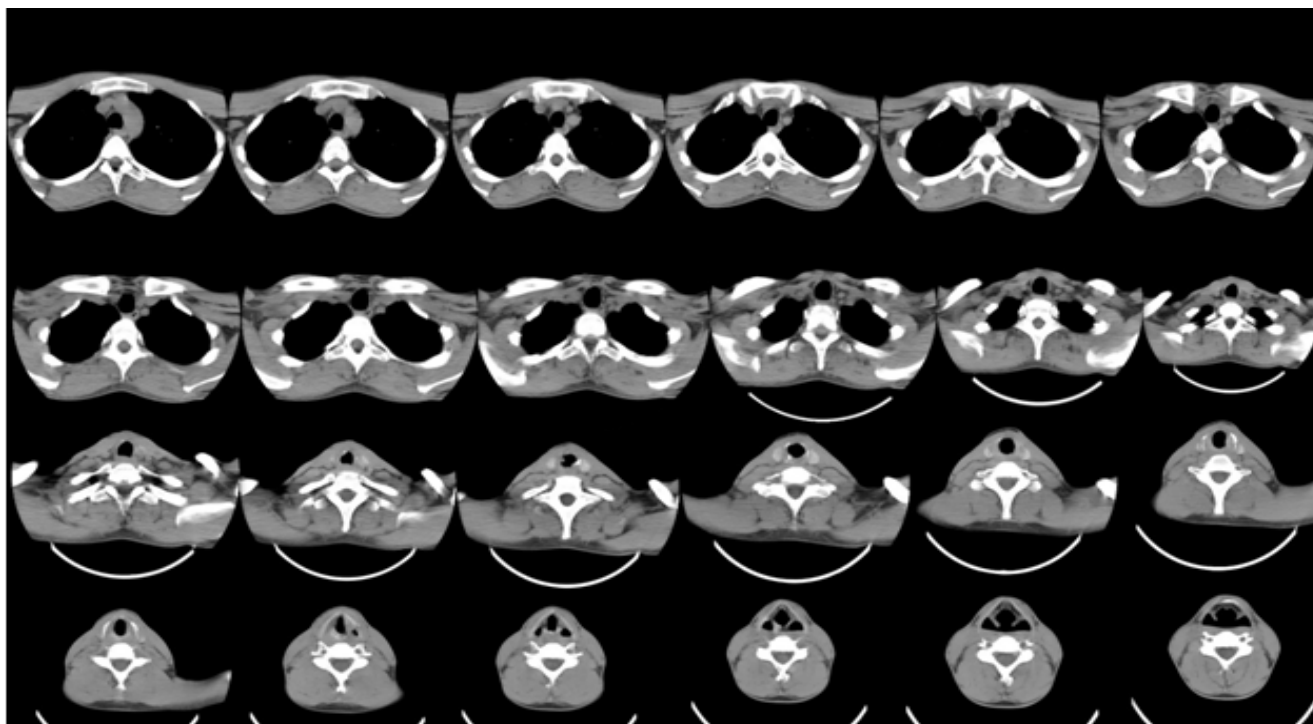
CT Neck 6 month post operatively
